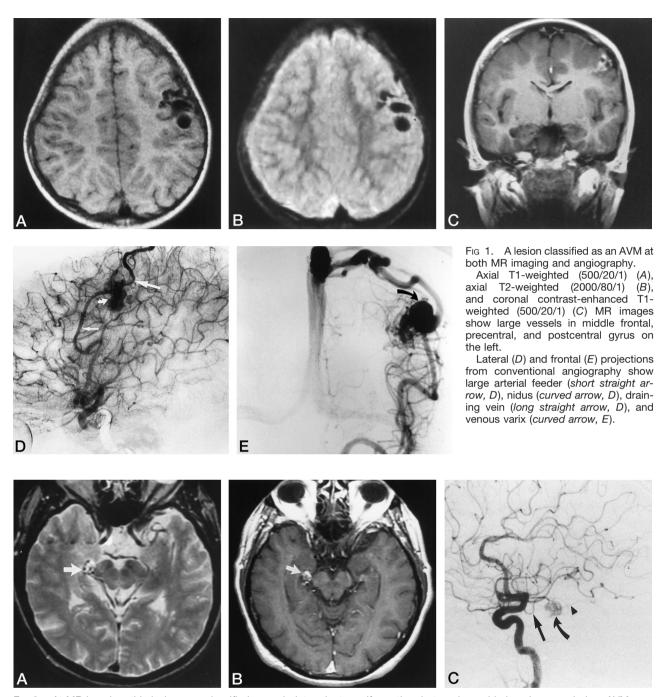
At MR imaging, this lesion was classified as an indeterminate malformation, but angiographic imaging revealed an AVM. Axial T2-weighted (2000/80/1) (*A*) and axial contrast-enhanced T1-weighted (500/20/1) (*B*) images reveal a partially enhancing lesion with heterogeneous signal in the right perimesencephalic cistern (*arrows*).
